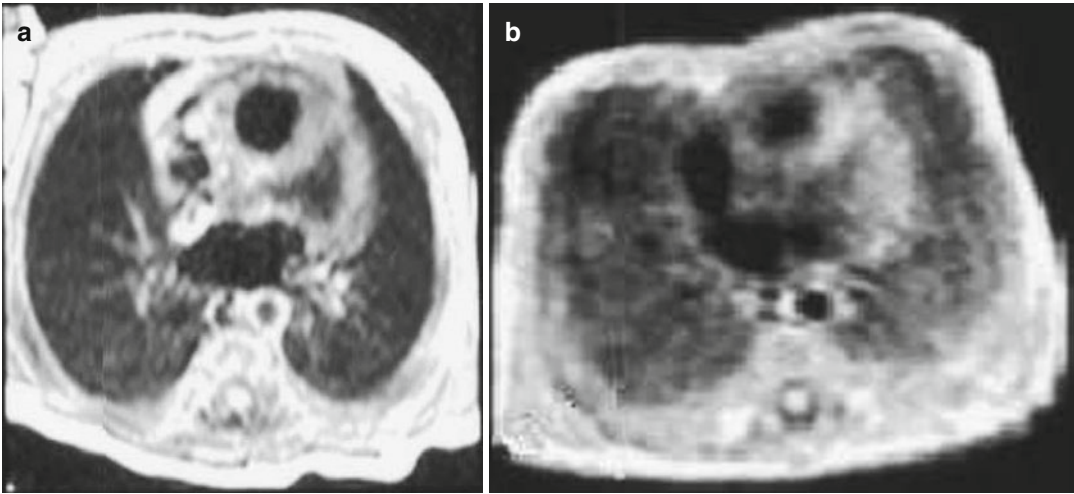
Magnetic resonance images of the term and preterm lung. Cross-sectional T1-weighted magnetic resonance images at the level of the left atrium in a healthy term infant (panel a) and 26-week gestation infants at day 4 of life (panel b). Signal intensity in the lung parenchyma is higher in the preterm infant, with a more obvious
